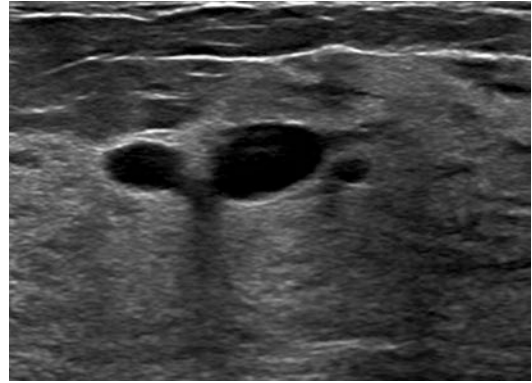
Ultrasound image of breast cysts with characteristic features (anechoic, well-defined back wall and posterior acoustic enhancement)
